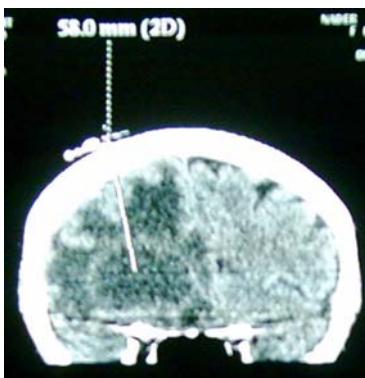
CT guided localization of the frontal abscess
